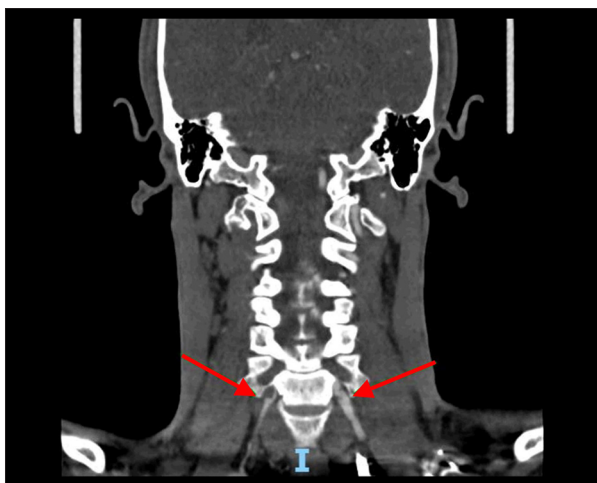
Computed tomography angiography of the neck and brain. Irregularities along with the cervical segments of the vertebral arteries (red arrows), more extensive to the right side where there are signs of subocclusion. The findings are consistent with recent arterial dissection.
